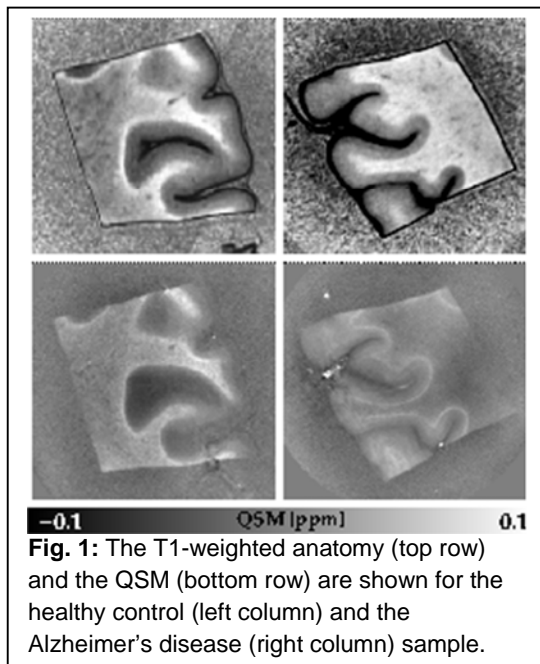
The T1-weighted anatomy (top row) and the QSM (bottom row) are shown for the healthy control (left column) and the Alzheimer's disease (right column) sample.
